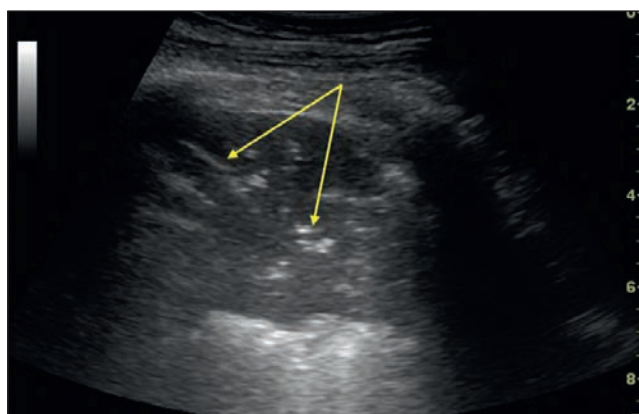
Ultrasound image of the lung consolidate (tissue-like sign), air bronchogram (arrows) (from the personal archive of G.V.Nekludova)
